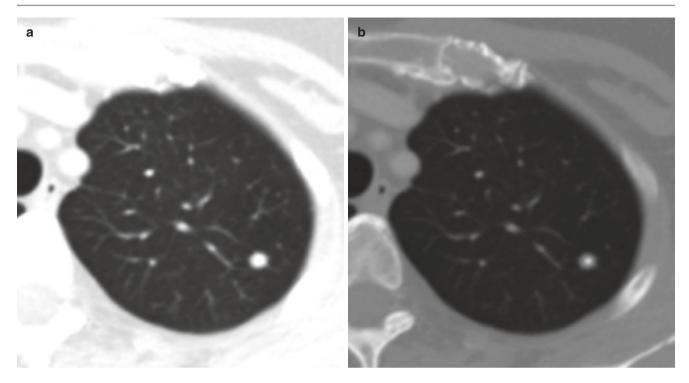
Centrally calcified granuloma. (a, b) Axial CT images show a well-circumscribed solid nodule with central calcification, typical of a healed granuloma
